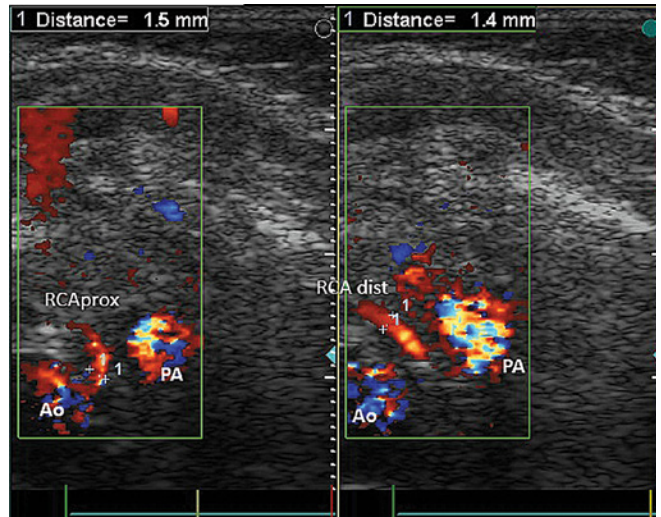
Postoperative ECHO. The initial segment of the right coronary artery in postoperative examination (18 days postoperatively). In order to achieve appropriate resolving power, a linear transducer was employed along with the color Doppler scale allowing representation of low flow rates (0.15m/s). Due to the arched course of the coronary artery making it impossible to capture the entire initial segment in a single image, two image frames are presented visualizing the consecutive fragments of the vessel. Uniform, laminar flow from the aorta (red color-coded) was visualized along the entire length of the examined vessel. Ao – aortic bulb, PA – initial segment of the pulmonary trunk, RCA – right coronary artery
